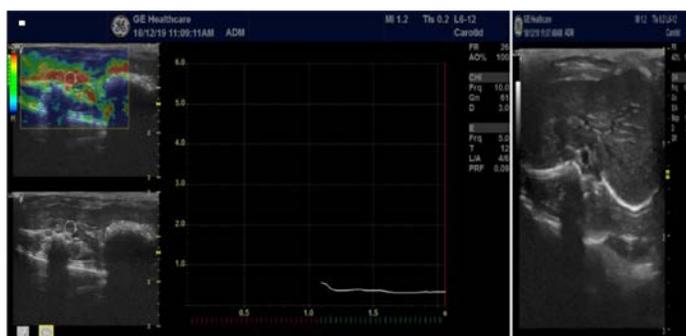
Elastography and Ultra Sonography of normal. Liver size: 1.6cm. Elastography score (pKa 0.8).
